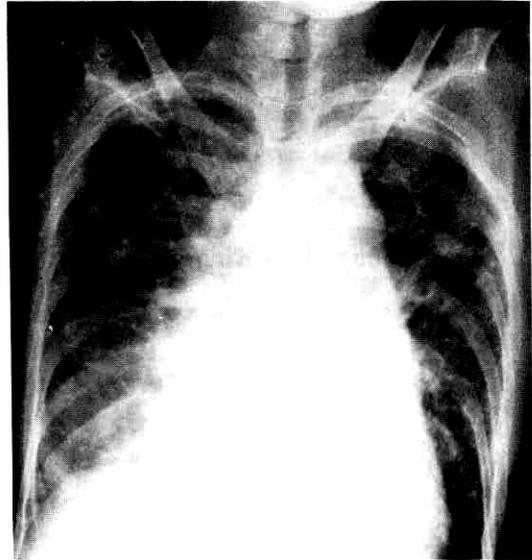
Chest roentgenogram disclosed an increased patch, parenchymal infiltration in left upper lung.
